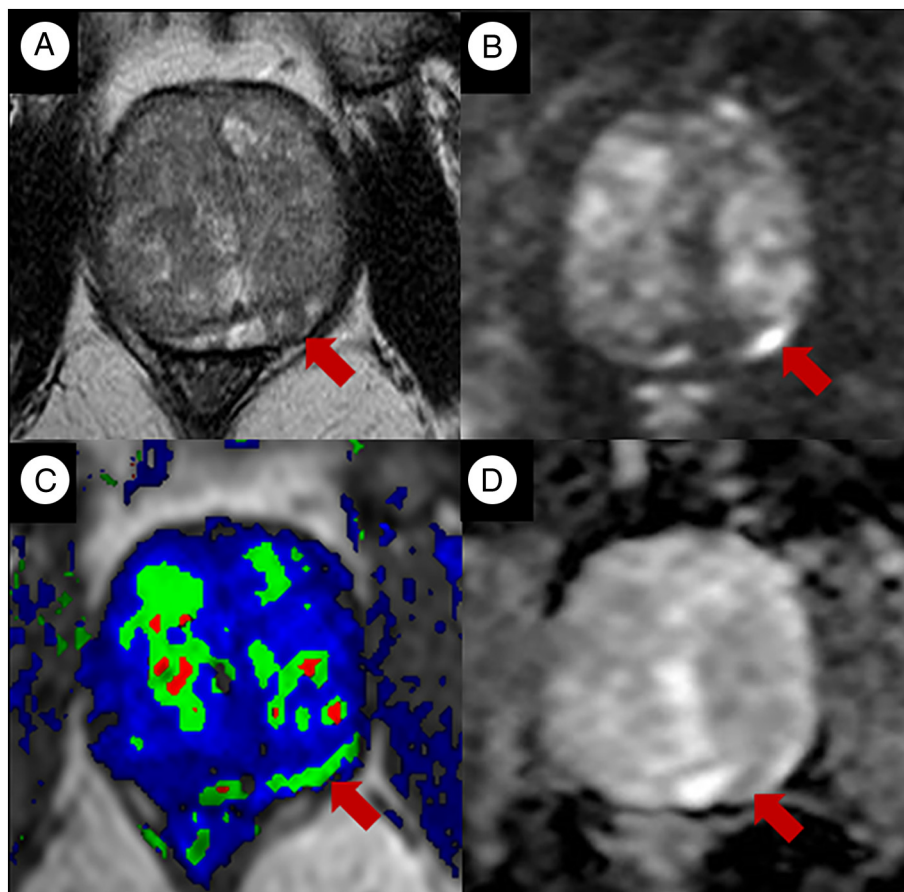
Left posterior mid-gland peripheral zone focal moderate hypointensity on ADC (red arrow, D) with corresponding mild hyperintensity on high *b*-value diffusion-weighted image (red arrow, B) corresponds to a circumscribed moderate hypointense focus on T2-weighted images (red arrow, A). There is also asymmetric perfusion (red arrow, C). This lesion is high suspicion for clinically significant prostate cancer (PIRADS 4).
